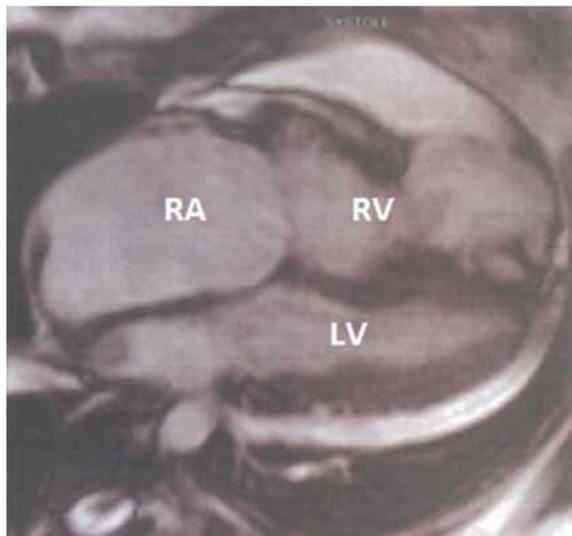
Cardiac MRI with contrast showing right ventricular trabeculations with pseudosacculations and dilatation.
